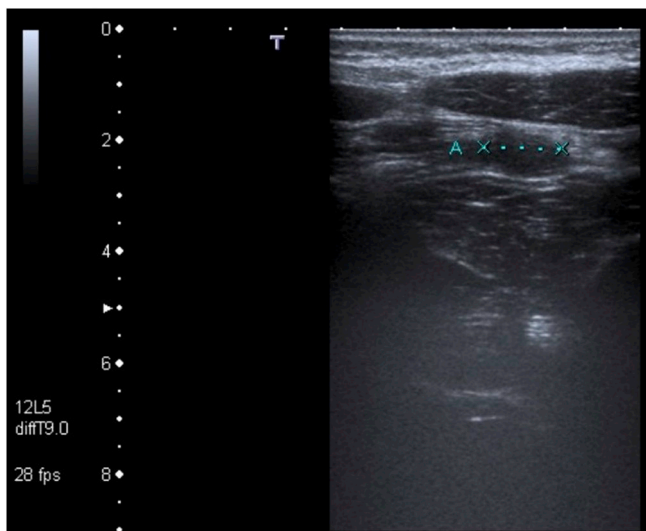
Longitudinal ultrasound scan showing tubular blind-ended structure measuring 21 mm of extension.
